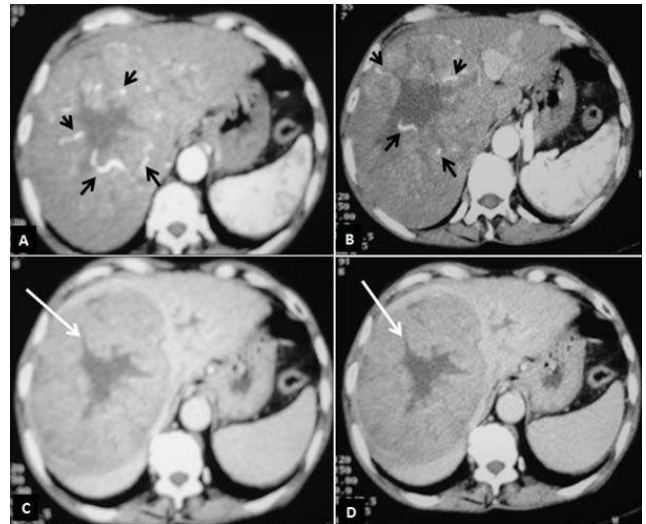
Axial abdominal CT with contrast injection (different vascular times: early arterial (A), late arterial (B), hepatic (C), and delayed phase (D)): heterogeneous aspect of the liver tumor (white arrow) with significant arterial blood supply (black arrows)
